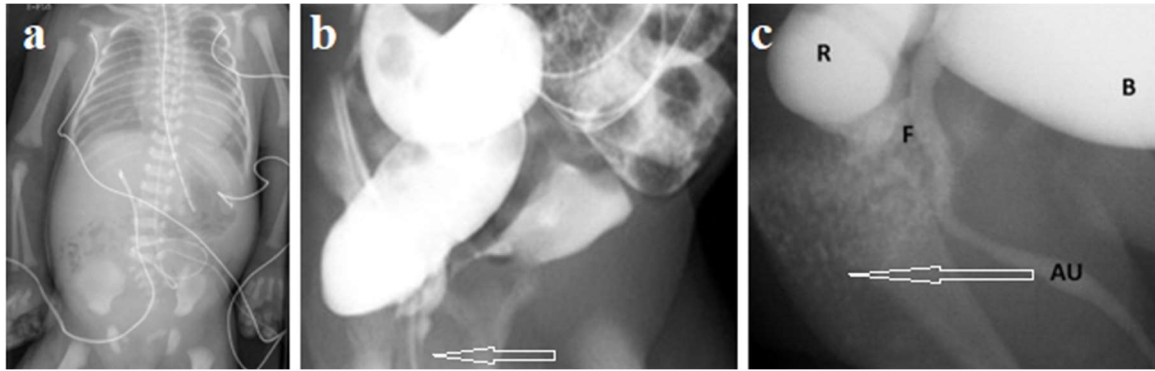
(a) Despite the anal stenosis (the anal opening was patent but admitted only a 9 mm Hegar dilator), the plain radiograph shows that bowel movement was not difficult. An X-ray examination was performed, since particulate matter was also found in the urine. (b) During barium enema the ano-urethral fistula, described as a colourethral fistula, was found. The anal canal is in a contracted state (arrow). (c) Pre-operative voiding cystourethrogram demonstrating colourethral fistula. Contrast medium diluted with urine is seen in the widely open anal canal (arrow). During posterior sagittal anorectoplasty (PSARP), a "quite large and patulous" prostatic fistula was found.
